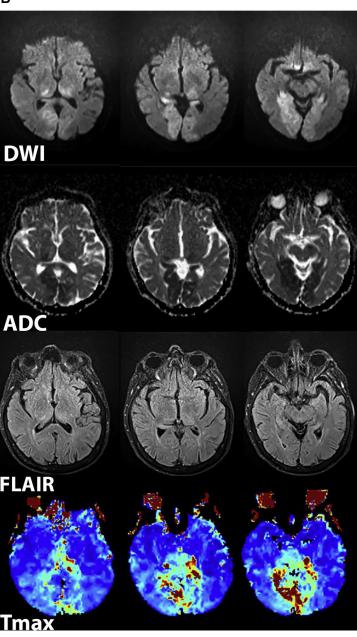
A 91-year-old woman with history of diabetes, atrial fibrillation, and hypertension presented with acute onset of severe headache and then became unresponsive. Baseline National Institutes of Health Stroke Scale (NIHSS): 26. Time from onset to imaging was approximately 2 hours. Sequential aligned noncontrast CT (A) and MR imaging DWI, apparent diffusion coefficient (ADC), fluidattenuated inversion recovery (FLAIR), and dynamic susceptibility contrast (DSC) time to maximum  $(T_{max})$  (B) and a coronal and sagittal maximum intensity projection from the contrast-enhanced magnetic resonance angiography (CE-MRA) image (C) are shown. There is a hyperacute infarction seen on DWI-ADC images involving bilateral posterior cerebral artery (PCA) territories, including bilateral thalami and occipital lobes. Note that the infarction is not seen on CT or FLAIR, which is suggestive of hyperacuity. There is matched perfusion deficit on DSC-T<sub>max</sub>. CE-MRA images show an absence of flow within the left vertebral artery, diminutive flow within the intradural segment of the right vertebral artery and proximal basilar artery, with occlusion and absence of flow within the distal basilar and proximal PCA arteries caused by acute basilar artery thrombosis.
